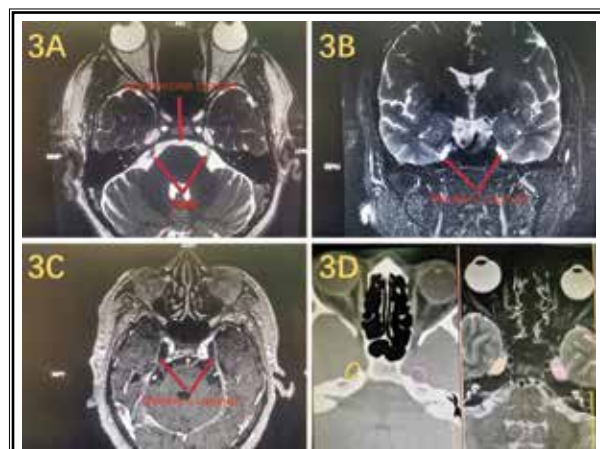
A) T2 image of MRI can clearly show the trigeminal nerve roots. B) T2 image of MRI can clearly show the Meckel's capsule where the gasserian ganglion of trigeminal nerve is located. C) T1 image of MRI can clearly show the Meckel's capsule where the gasserian ganglion of trigeminal nerve is located. D) CT/MRI image fusion can show the Meckel's capsule.
